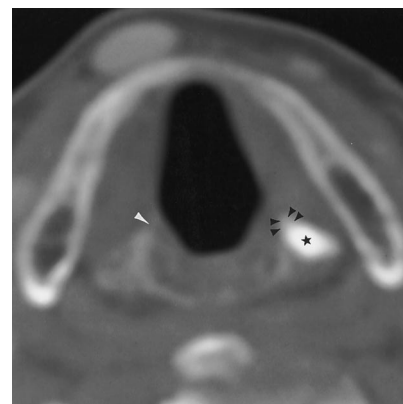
CT scan in an 80-year-old woman at the level of the vocal process of the arytenoid cartilage obtained in a bone window shows marked sclerosis of the body of the arytenoid cartilage (*star*) as well as of the vocal process (*black arrowheads*) on the left side. The vocal process on the right (*white arrowhead*) is normal in appearance. This study was obtained for staging of a hard-palate lesion, which proved to be a carcinoma in situ at pathologic examination.
